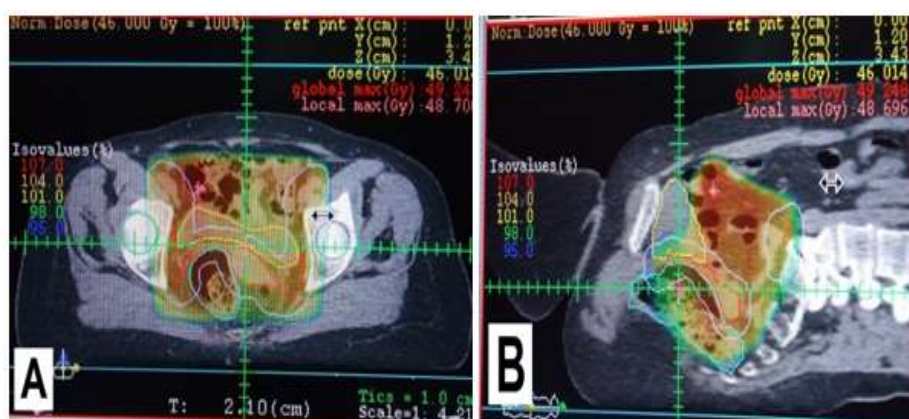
CT-scan dosimetry imaging. (A) Axial view and (B) sagittal view showing dose distribution of external beam radiation to the Planning target volume (PTV).
